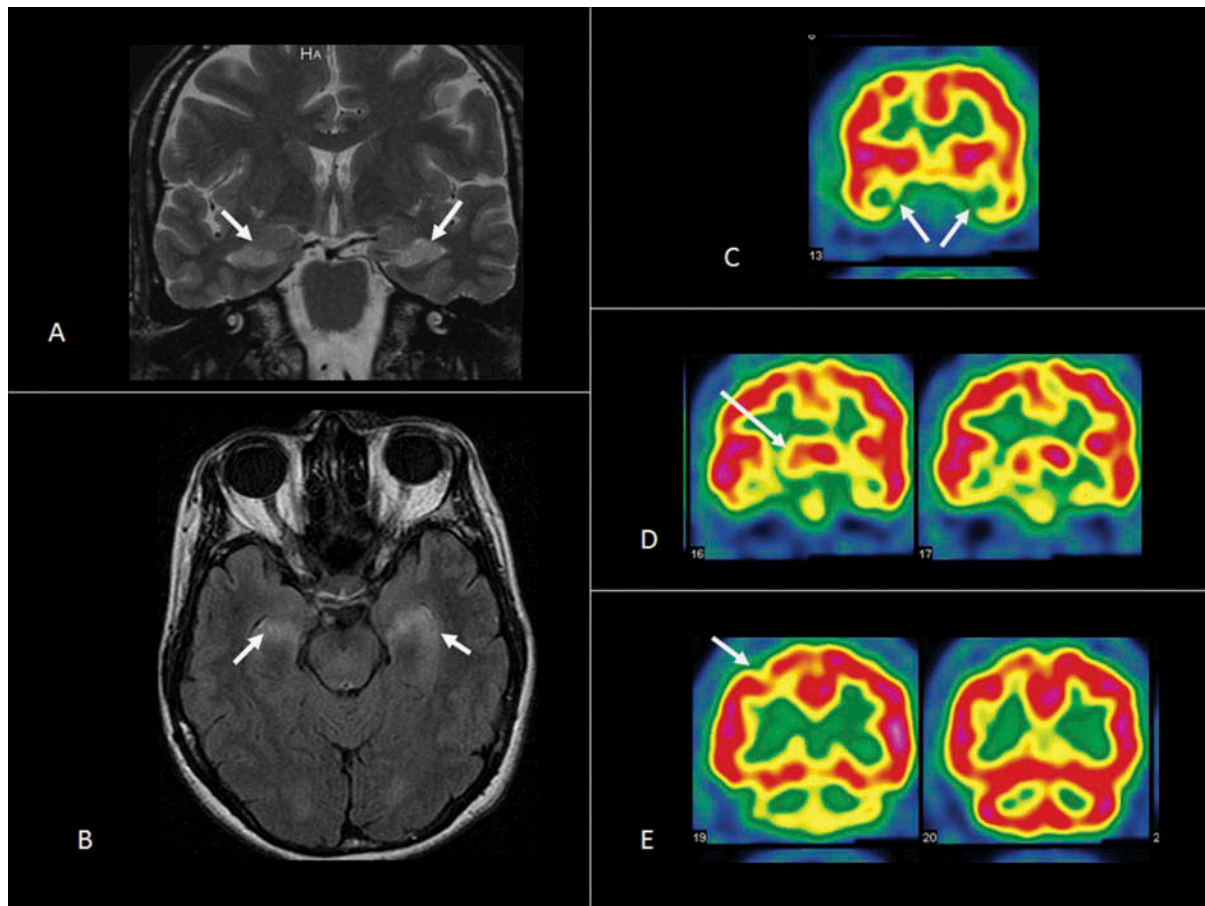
Imaging findings: MRI: T2 (A) and FLAIR (B) hypersignal of bilateral medial temporal lobe (hippocampus and amygdala). SPECT: Hypoperfusion of bilateral medial temporal cortices (C), right thalamus (D), and right sensitive motor cortex (E). [To view this figure in color, please see the online version of this Journal].
